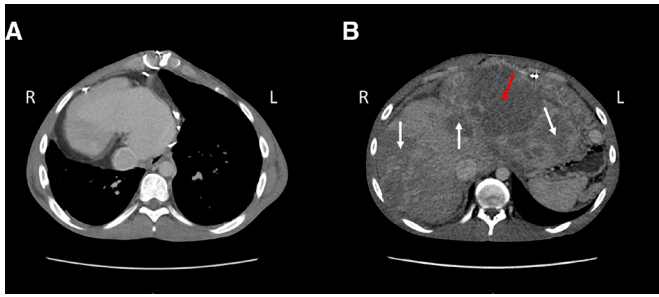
Axial CT image of (A) dextrocardia with single effective ventricle and (B) multifocal, diffuse hepatocellular carcinoma (white arrows), with the largest mass measuring 12×8 cm (red arrow).
